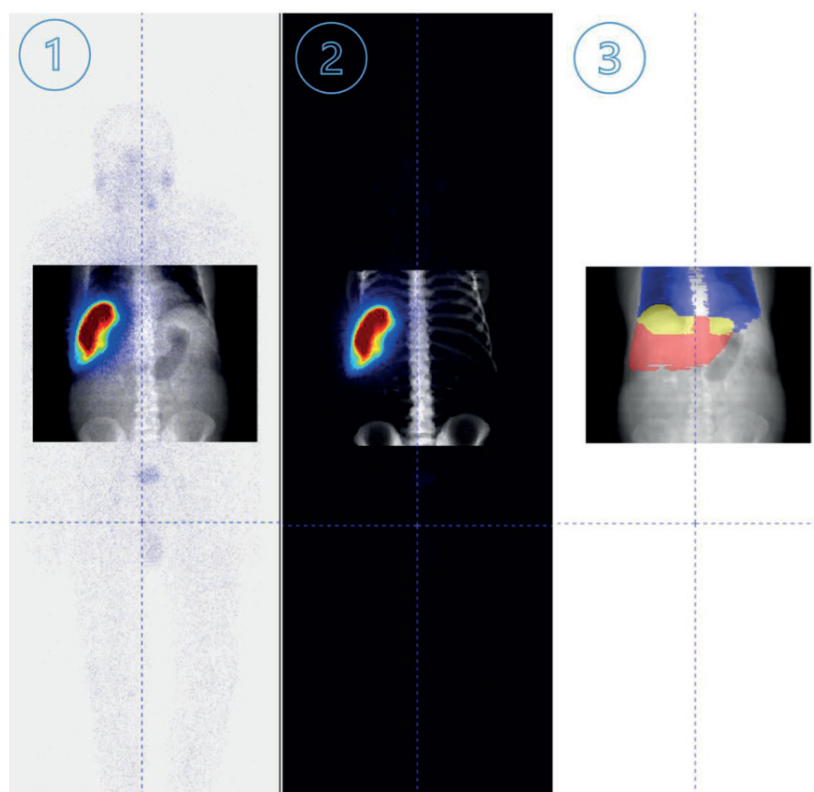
Example of co-registered images and viewing method adopted for the calculation of LSF. (1) TB planar image and the CT projection fused, (2) TB planar image and bone segment projection, (3) CT projection image, lung (blue), liver (red) and their overlaps (yellow) segmentations.
